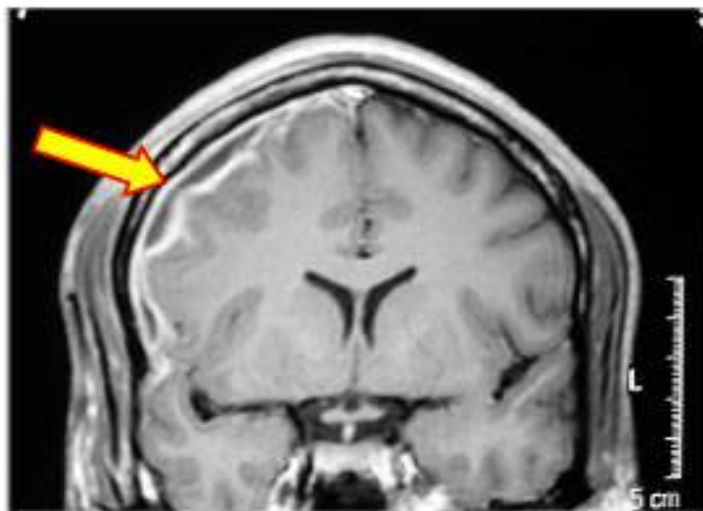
Magnetic resonance imaging revealing a right subdural empyema with meningeal enhancement.
